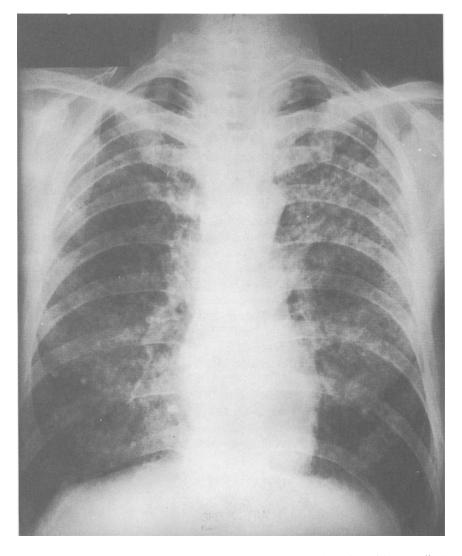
Miliary tuberculosis. Radiograph courtesy of Maimonides Medical Center Radiology Department.
